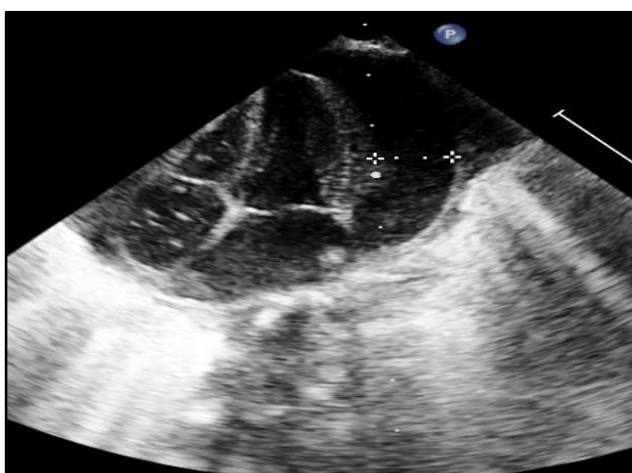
2D Echocardiogram Apical 4 Chamber View Showing Pericardial Effusion
